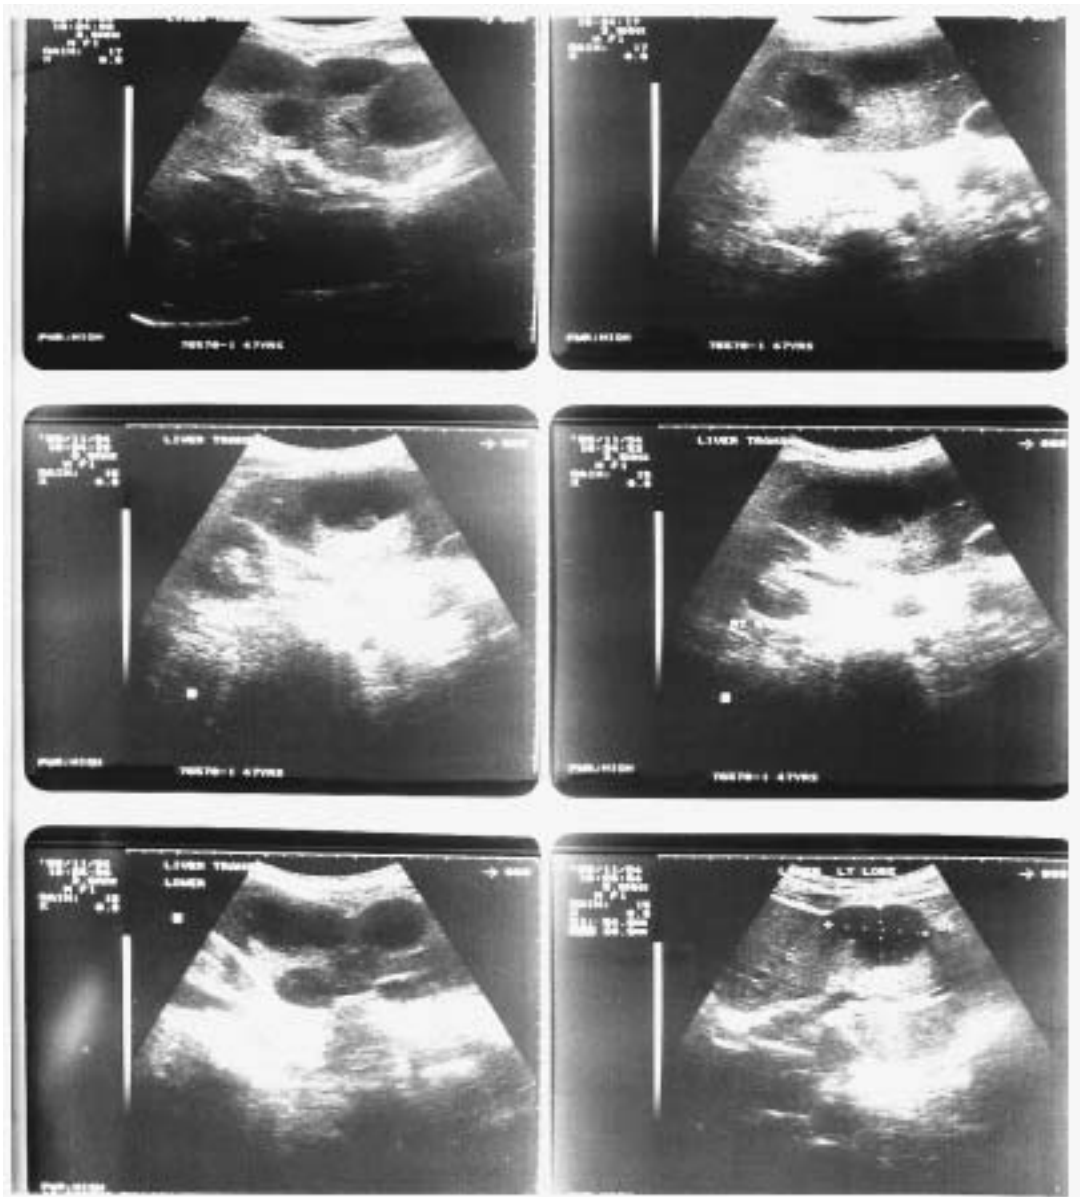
Ultrasound scan of the liver 12 days after initial presentation.
